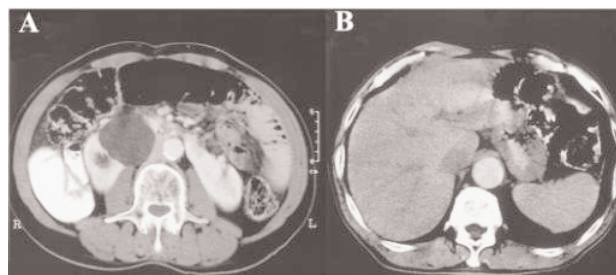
Contrast axial CT scan in patients with crossed, fused renal ectopia showing a right kidney cyst of 28 mm. No signs of intra-abdominal hemorrhage, choledochus compression or dilatation of the intra-hepatic biliary tract are evident.
